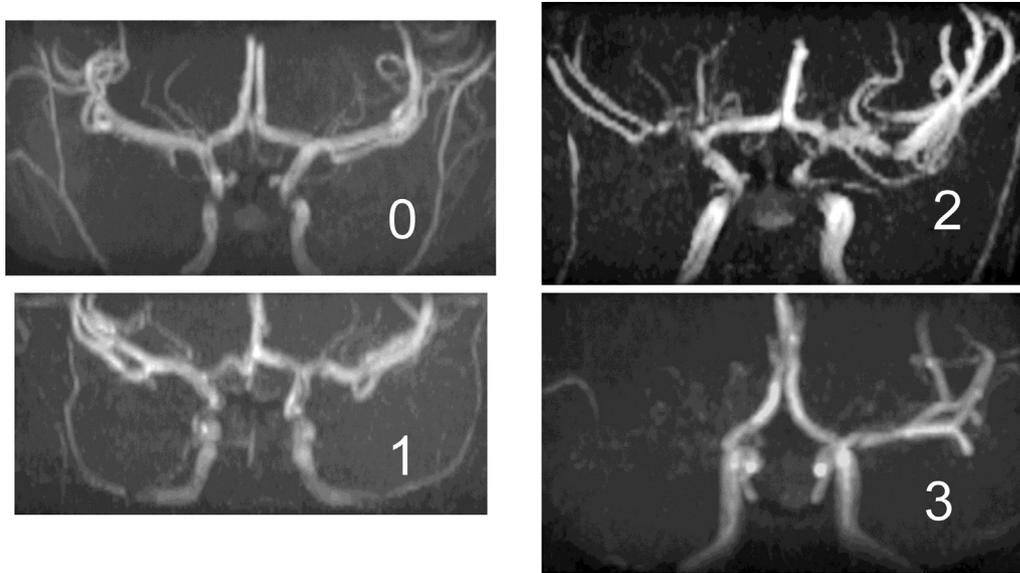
Vasculopathy on magnetic resonance angiography graded according to the severity of signal loss in neurologically asymptomatic children with sickle cell disease: Grade 0, normal; Grade 1, minor signal attenuation (turbulence) and normal appearing vessel on magnetic resonance imaging; Grade 2, obvious signal attenuation, but presence of distal flow (stenosis); Grade 3, signal loss and no distal flow (occlusion); Grade 4, occlusion with collaterals (moyamoya), not shown.
